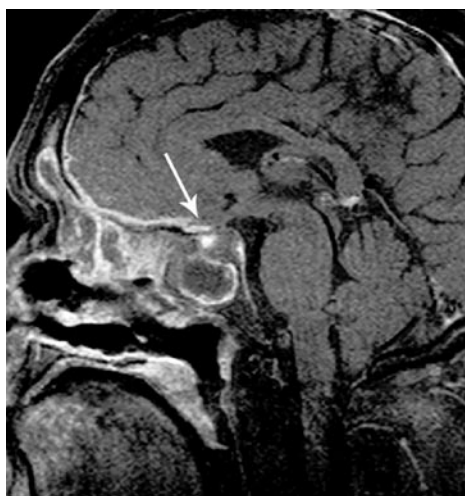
A 52 year old patient with known WG and new development of polyuria and polydipsia. Contrast-enhanced T1-weighted MR image shows enlarged pituitary gland and enhanced inflammatory mass in the sphenoid sinus.
